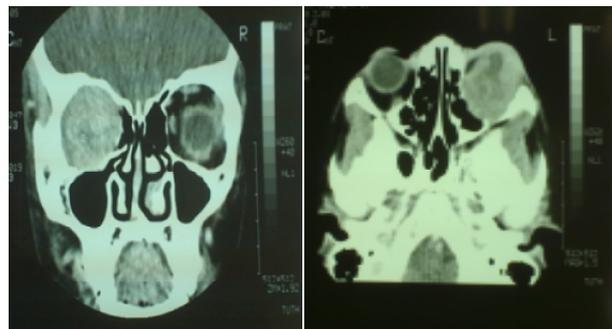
CT scan of orbit and head showing widening of orbit with orbital mass eroding of medial wall
